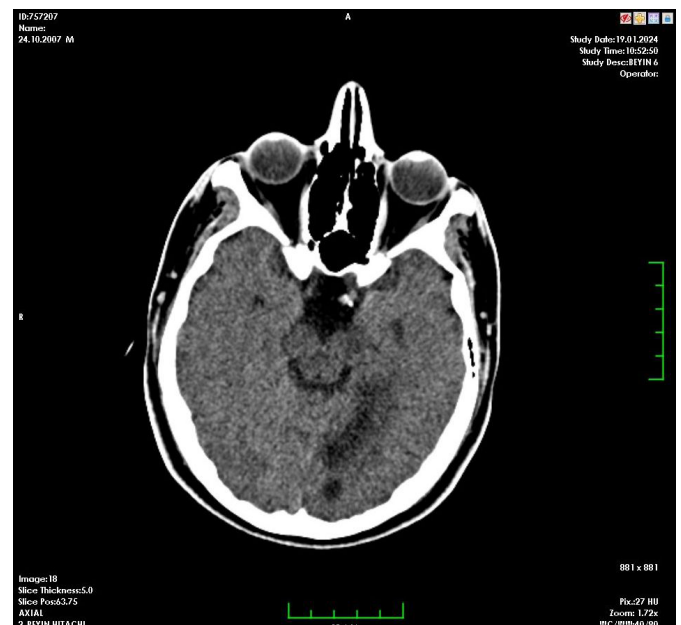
When the patient came for a check-up after receiving inpatient treatment, areas of chronic ischemia were seen on the CT images taken in our hospital
